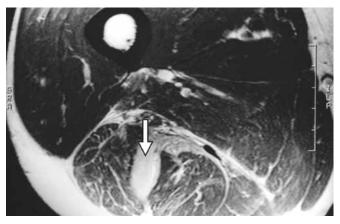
Muscle belly injury seen on axial proton-density-weighted MR image as an intramuscular hematoma in the biceps femoris muscle (arrow).
